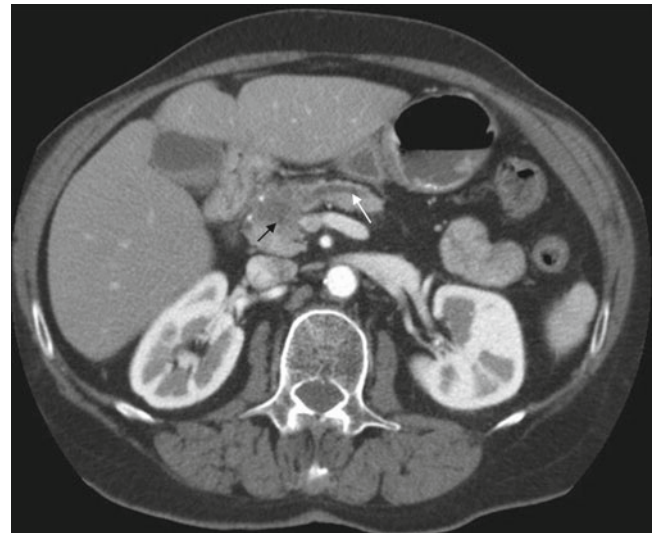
A 79-year-old man presents with epigastric discomfort associated with weight loss, light colored stools, and dark urine. Axial intravenous contrast enhanced CT image at the level of the head of the pancreas shows a 1.5 cm low attenuation area in the head of the pancreas (*black arrow*) with pancreatic duct dilatation (*white arrow*), suggesting an adenocarcinoma of the pancreas. Diagnosis: Pancreatic cancer
